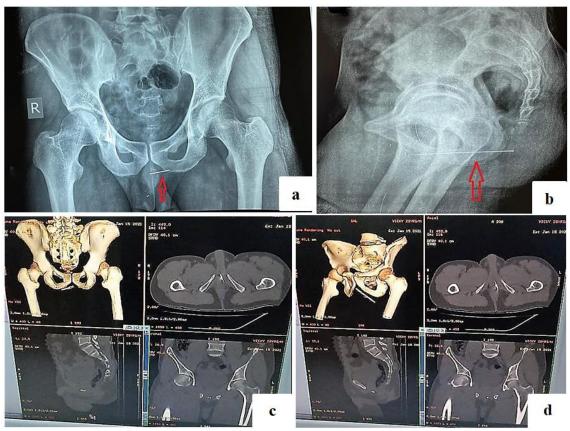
Plain pelvic radiography (Anteroposterior (a) and lateral (b)) showing a radio-opaque foreign body (arrow) below the pubis. Other radiographic images anterior or ventral view (c) and lateral view (d)
